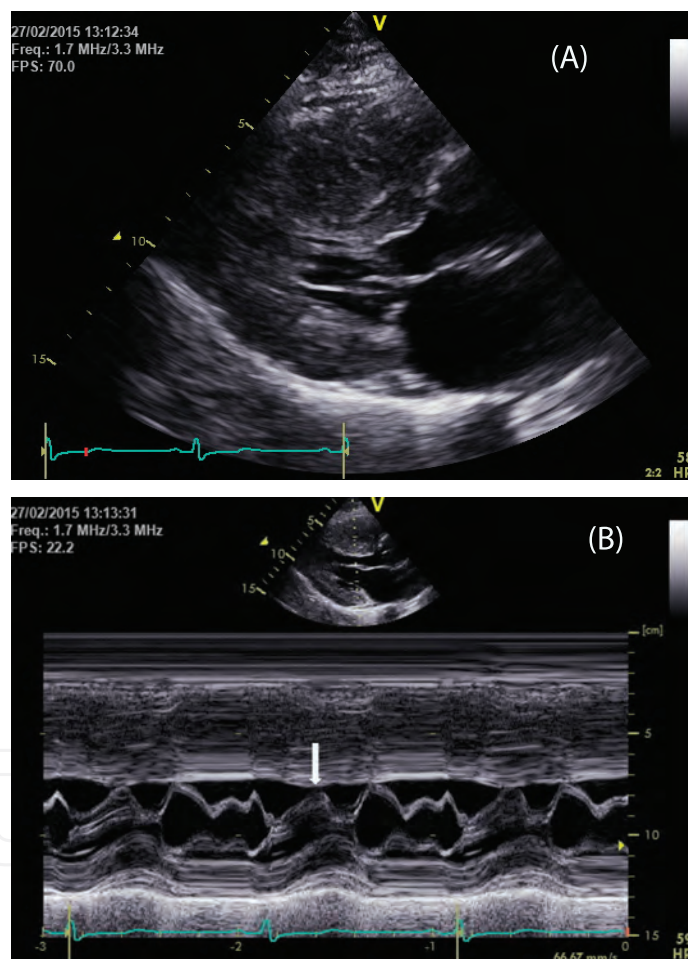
Systolic anterior motion (SAM) of anterior mitral leaflet at mid to late systolic phase (A) parasternal long axis view, 2D; (B) parasternal long axis view, M-mode.
